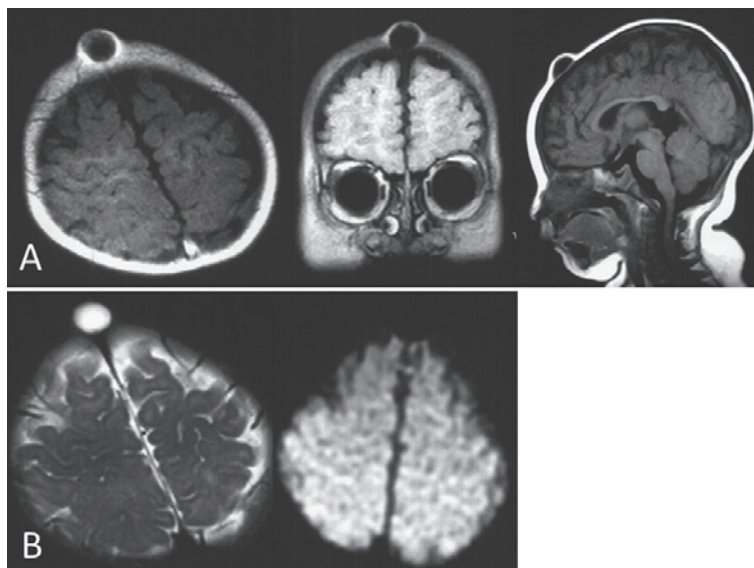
A) T1-weighted imaging showing a low-intensity tumor on the superior sagittal sinus. B) T2-weighted imaging and DWI showing high- and low-intensity lesions, respectively. The tumor borders on the dura, which is continuous under the tumor.
